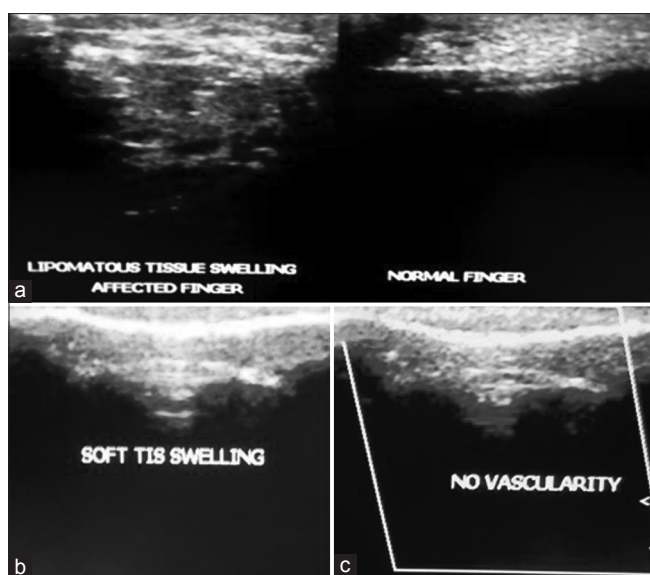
(a) Ultrasonography (USG) and Colour Doppler study of left hand revealed increased echogenic soft tissue component suggestive of fatty tissue without any significant internal vascularity. (b) Similar details found in USG and Colour Doppler study of left foot. (c) Similar details found in USG and Colour Doppler study of right forearm and hand
